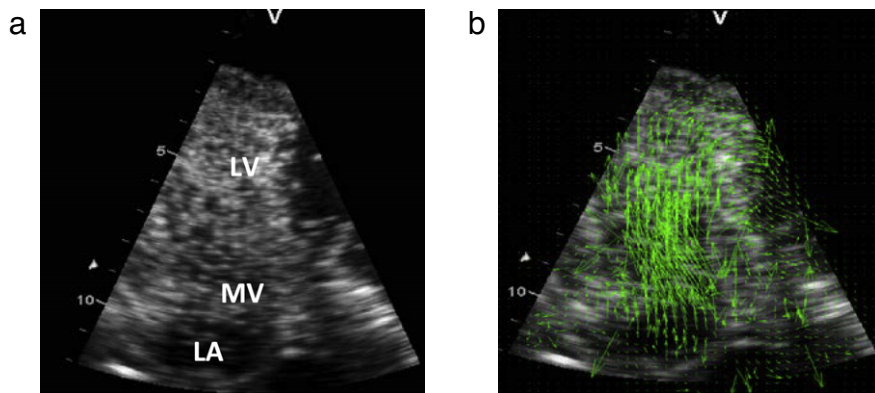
An ultrasonogram of the left ventricle (LV), mitral valve (MV), and left atrium (LA) after injecting microbubbles (a). The corresponding echo-PIV data (velocity vectors) (b).
